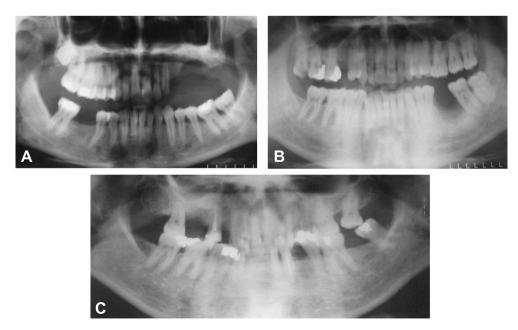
Postoperative panoramic radiographs showing the healing of bone in the (A) left maxillary premolar, (B) left mandibular molar, and (C) maxillary molar regions of Case 1, Case 2, and Case 4.
